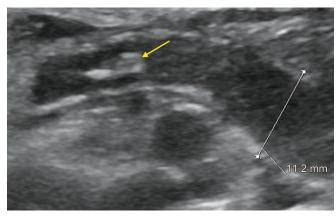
Transabdominal ultrasound of right lower quadrant reveals a tubular sonolucent structure measuring 11.2 mm in its maximum diameter. An echogenic appendicolith with mild posterior shadowing is visualized in the proximal lumen (pointed by an arrow)
